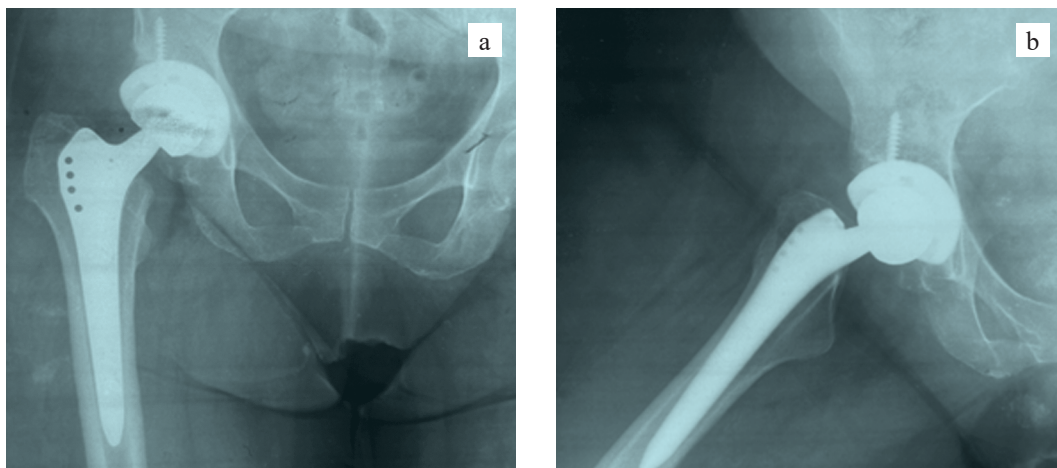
X-ray six months after total hip arthroplasty of the right hip (Zimmer–Biomet cementless endoprosthesis, IT cup, Alloclassic stem): a, hip joint in neutral position; b, hip joint in abduction position
